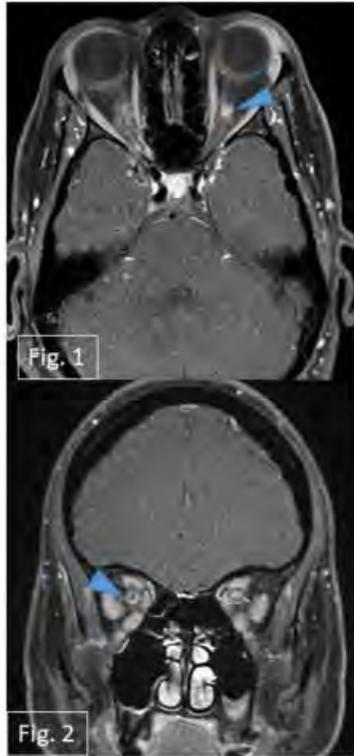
is an axial post contrast T1 MRI image of the orbit showing thickening and enhancement of the left optic nerve (blue arrow head)
